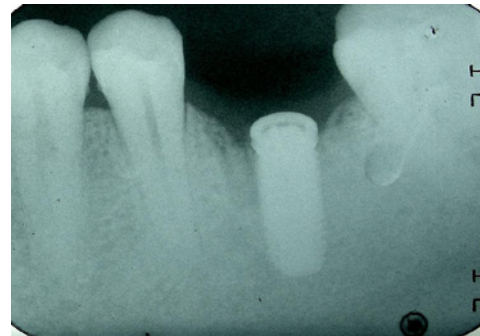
Periapical post-surgical radiograph.
